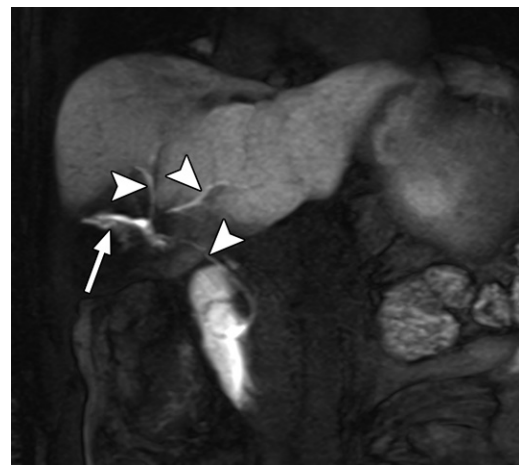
Gadoxetate bile leak imaging in a 28-year-old patient with a gunshot wound. Coronal T1-weighted HBP MR image obtained 60 minutes after the administration of gadoxetate shows leak of biliary contrast agent at the hepatic hilum (arrow) out of the normal biliary tree (arrowheads) from a gunshot injury.
